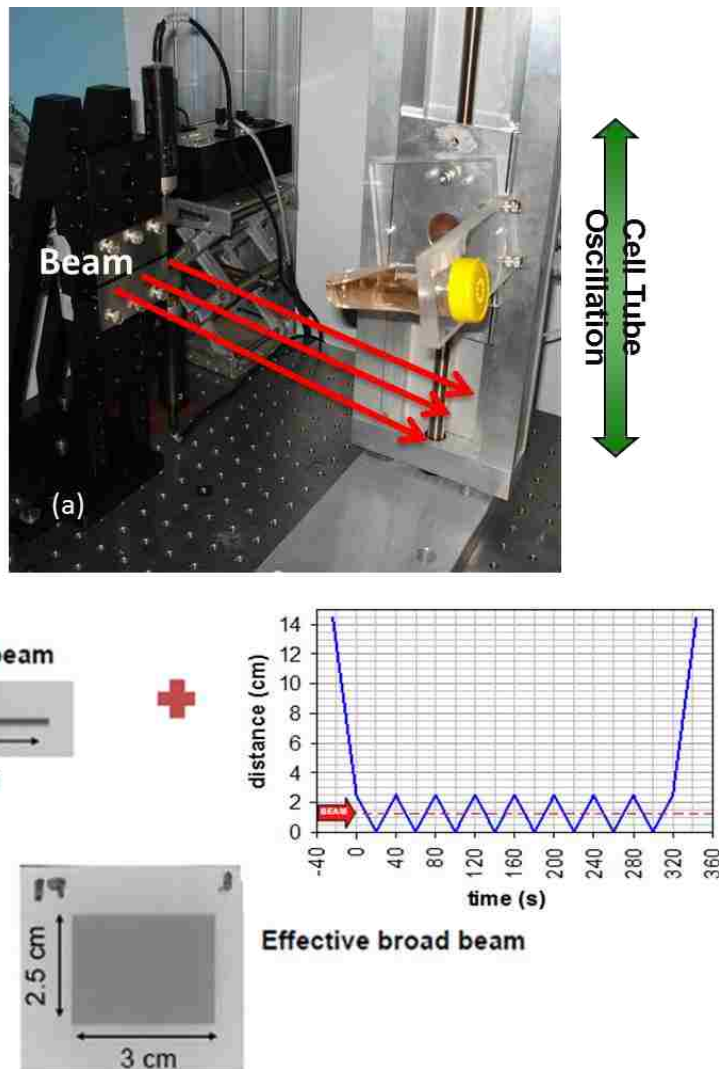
Broad beam production. (a) A screw-drive motion stage, with a cell culture test tube attached, oscillates through the monochromatic x-ray beam producing a broad beam in the reference frame of the cell culture test tube. (b) An effective broad beam approximately $3.0 \times 2.5 \text{ cm}^2$ was achieved by vertically oscillating the stage through the path of the “strip” beam at $0.125 \text{ cm} \cdot \text{s}^{-1}$ using a triangular function (courtesy of Dr. Joseph Dugas).
